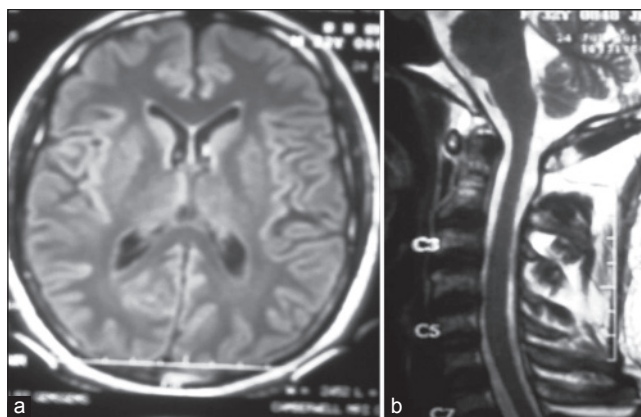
(a) Magnetic resonance imaging (MRI) brain-normal. (b) MRI cervical cord-normal
